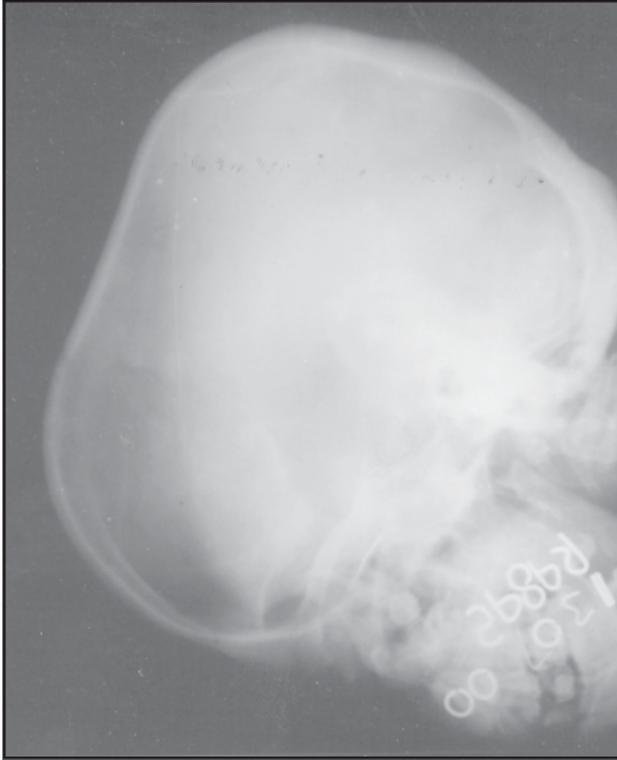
Skull X-ray showing hyperostosis, large boot shaped sella turcica.
